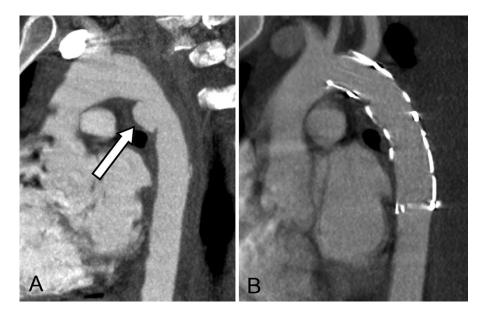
A, Computed tomography angiography (CTA) showing an acute posttraumatic pseudoaneurysm (arrow) of the thoracic aorta at isthmus. B, Complete exclusion of the pseudoaneurysm by a 24-mm \times 104-mm Relay Thoracic stent graft, with bare-metal overstenting of the left subclavian artery (LSA).
